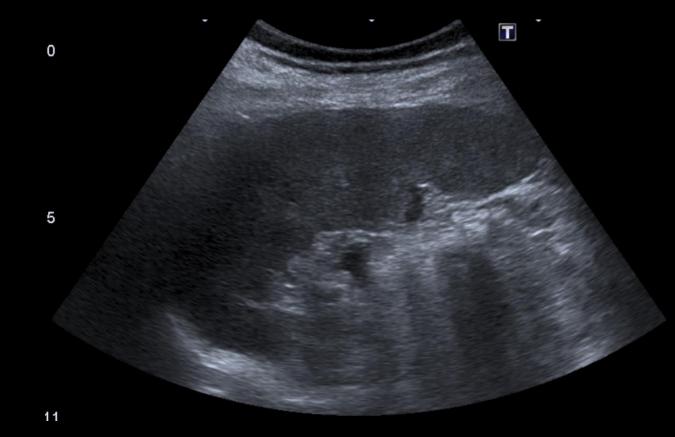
Ultrasound. Splenomegaly (16 cm).
